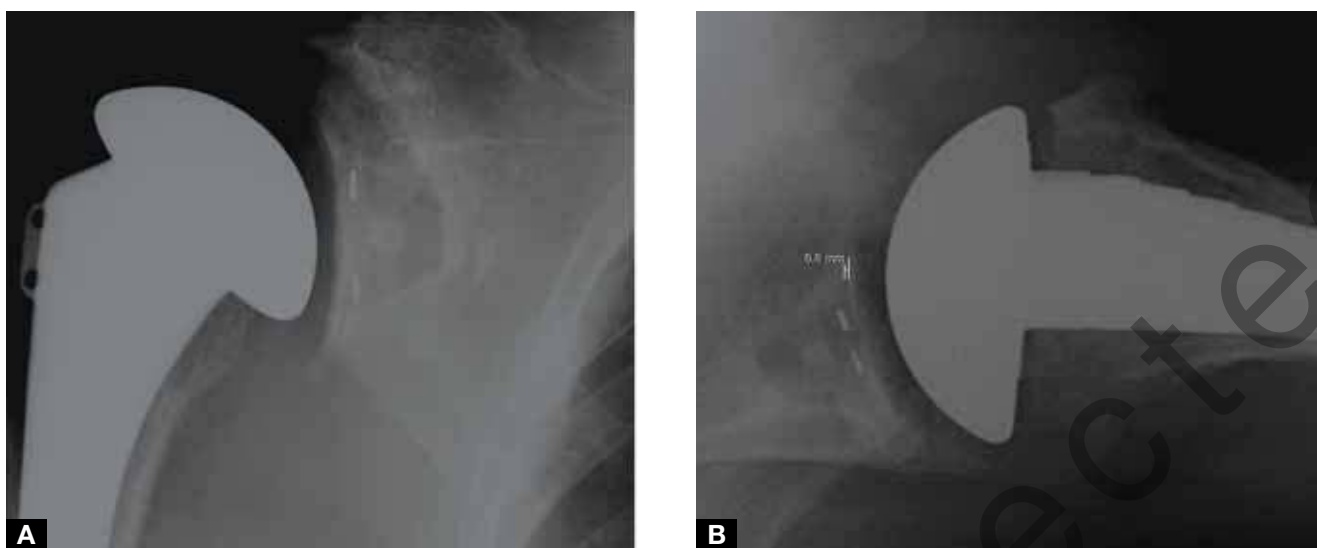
Representative radiographs with evidence of radiolucent lines in (A) zones 1 and 5 (anteroposterior view) and (B) zone 1 (line width, 0.8 mm; axillary lateral view).
